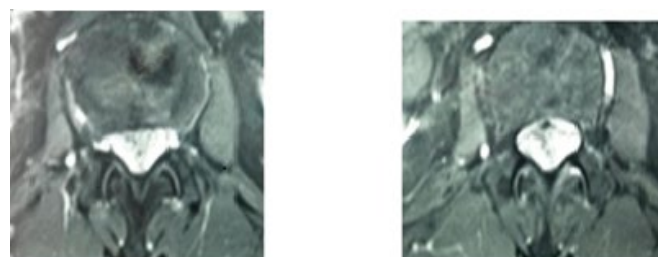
Spinal MRI T1 weighted axiale with gadolinium T2 homogenous enhancement in dura matter, the lumbar segments of the spinal cord and conus region homogenous enhancement in dura matter and in the filum terminal after intravenous contrast.
